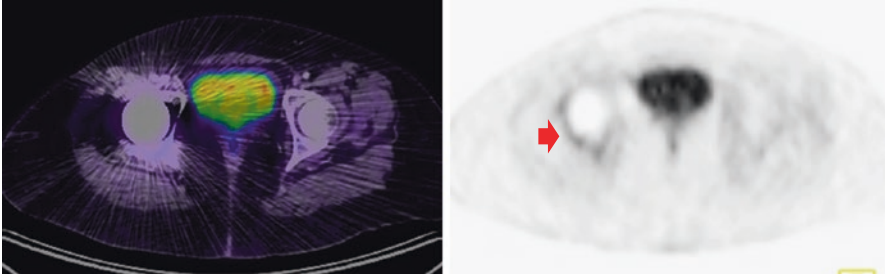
Artefact due to metallic orthopaedic implant in the right femur. The CT-based attenuation map corrects (or overcorrects) photopenic areas adjacent to high-attenuation structures and makes them appear hypermetabolic on the attenuation-corrected PET images (*red arrow*). Review of PET images alone and attenuation noncorrected images would be helpful
